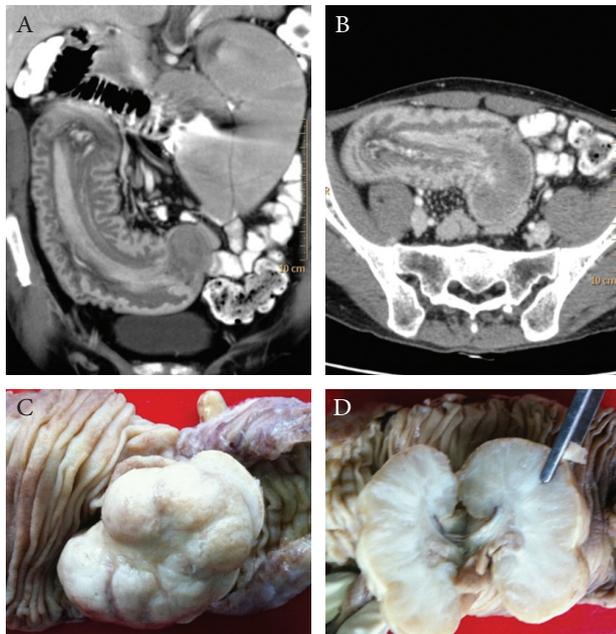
(A, B) Coronal and axial contrast enhanced computed tomography scan images revealing jejuno-jejunal intussusception with homogeneously enhancing polypoidal neoplastic lesion at lead point. (C, D) Small bowel polyp on external and cut surface, respectively
